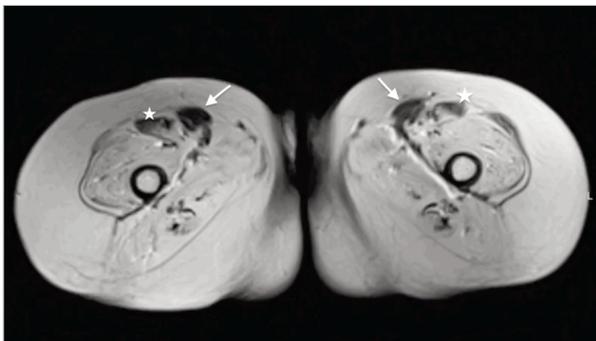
Axial T1-weighted image showing near complete replacement by fat of the quadriceps muscle bilaterally with a relative spare of the rectus femoris muscle (stars) and the sartorius muscle (arrows)
